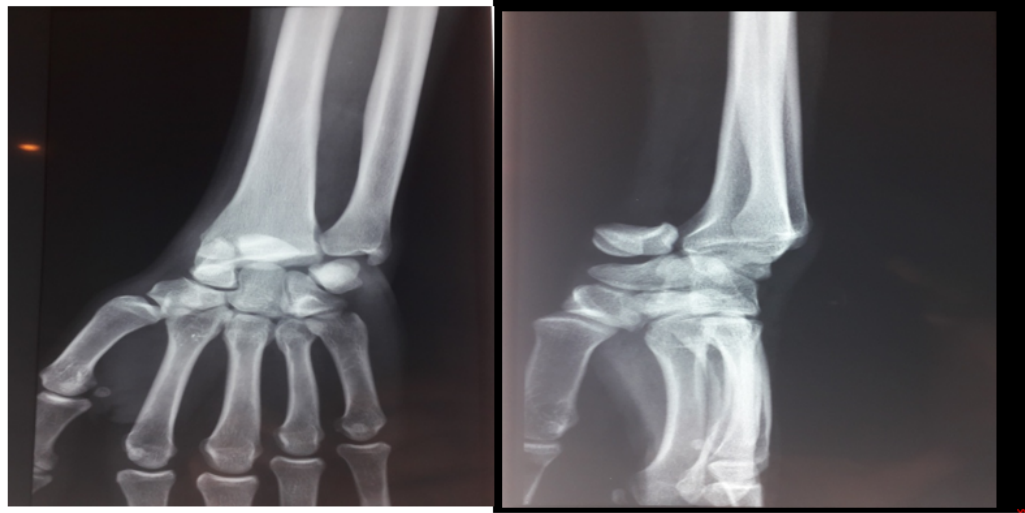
X-rays showing a trans-scapho-retro-lunar dislocation fracture.
